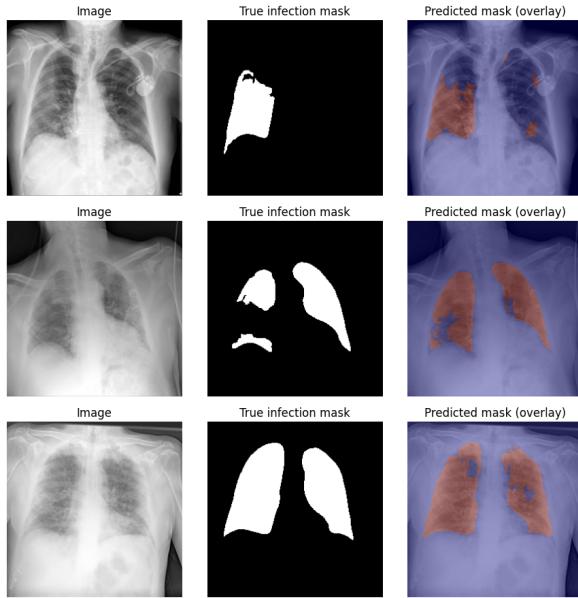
Sample predictions: original X-ray (left), true infection mask (middle), predicted mask overlay (right).
